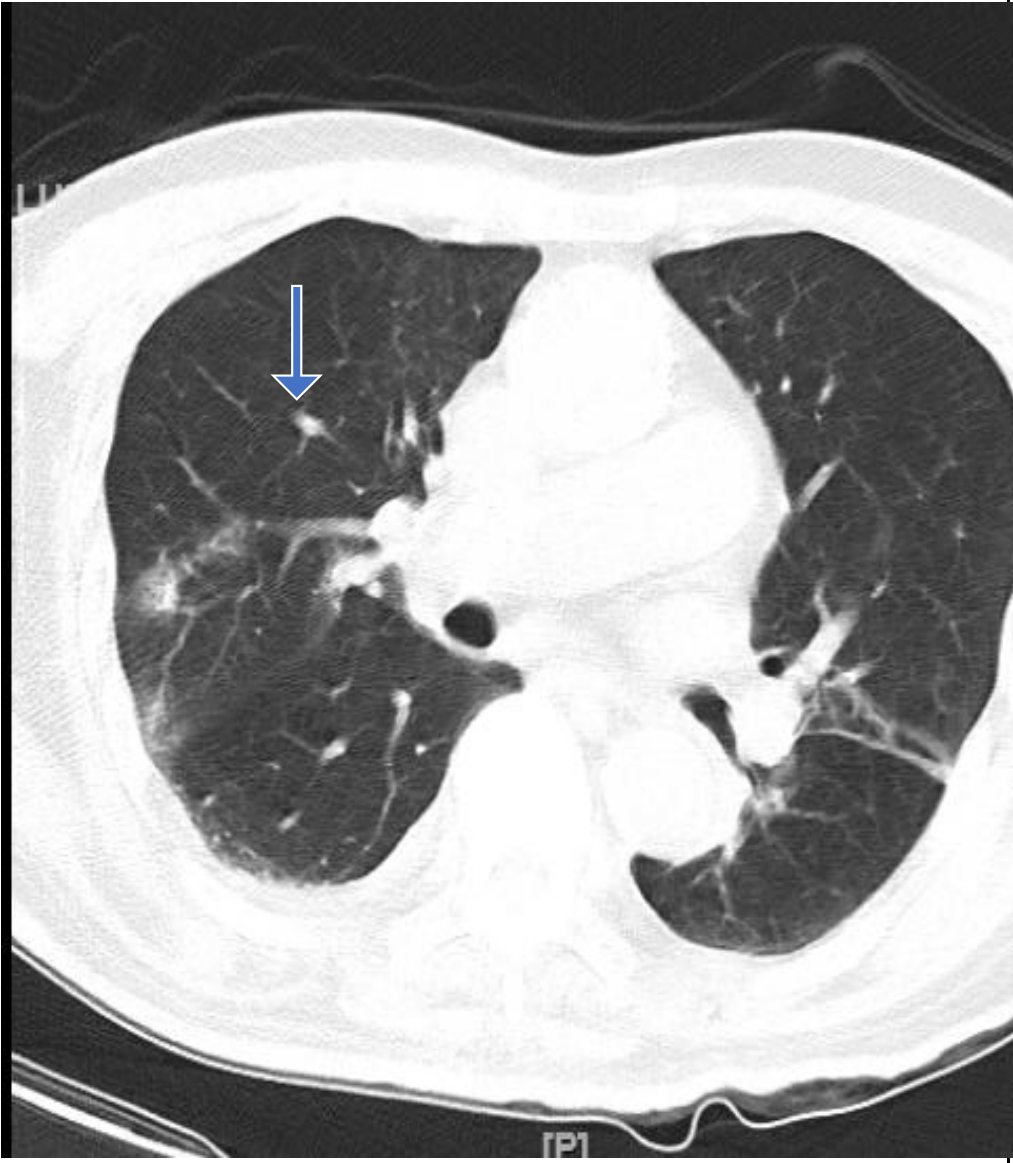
CT Scan: On Day 1:
